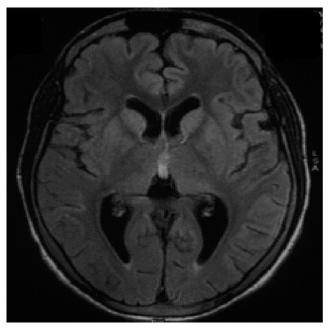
Axial FLAIR magnetic resonance imaging of brain showing hyperintensities in bilateral basal ganglia and thalamus.
